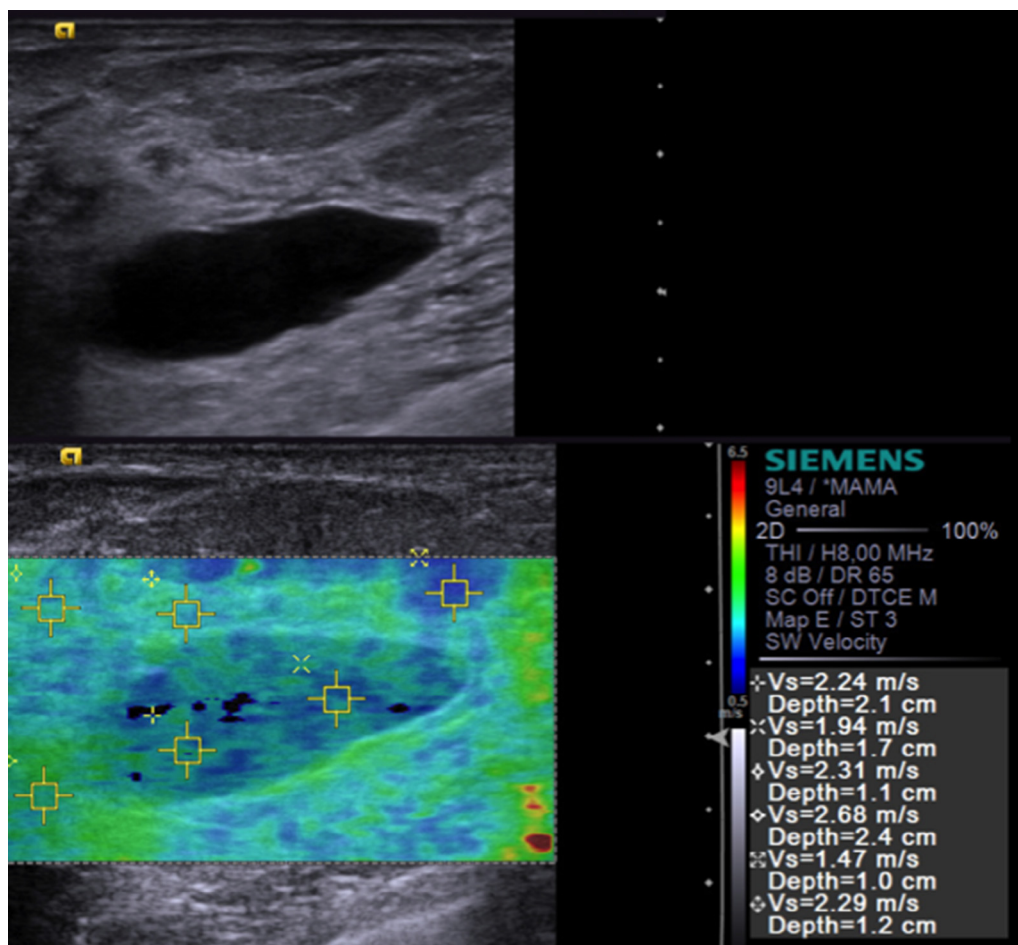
B-mode ultrasonography depicts a homogeneous, anechoic, oval lesion (simple cyst). The color elastogram shows a heterogeneous appearance, with “black areas.”
